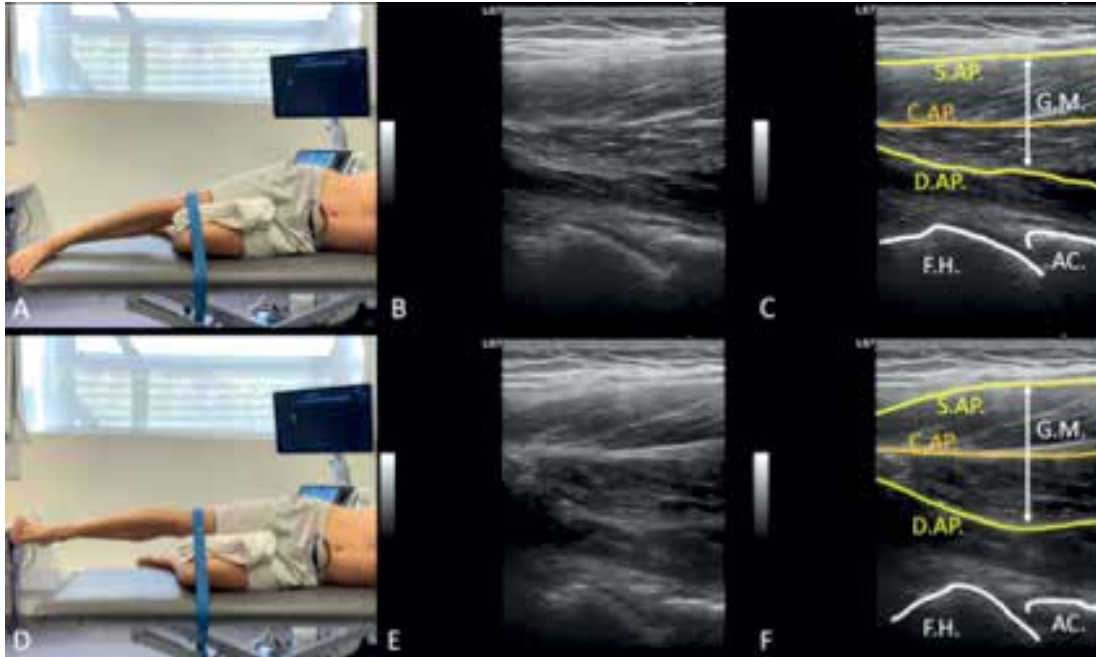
USI assessment for gluteus medius muscle at rest and during muscle contraction. Ultrasonographic evaluation of gluteus medius muscle at rest and during muscle contraction phase. Side lying on the side at rest (A) for identification of the hip joint and the gluteus medius and its connective tissue as a point of measurement of the thickness at rest (B, C). Side lying on the side in muscle contraction state with resistance at knee level (D) for identification of the hip joint and the gluteus medius and its connective tissue as a point of measurement of the thickness at muscle contraction (E, F)
